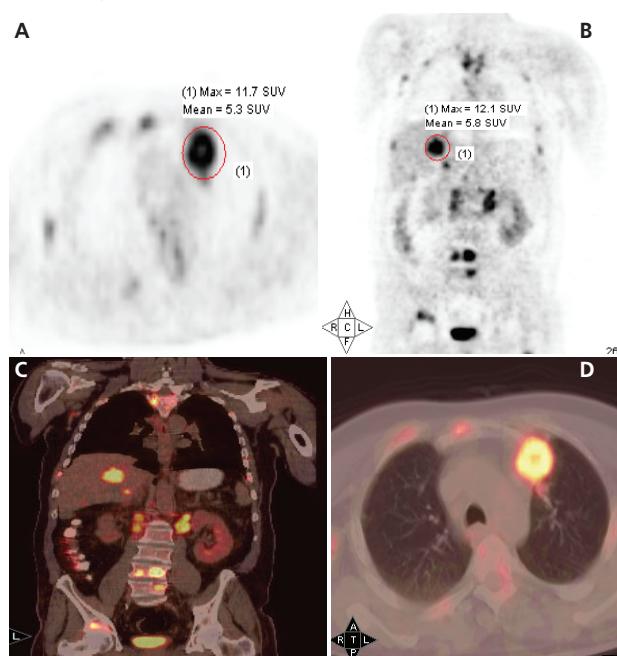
A patient with non-small cell lung carcinoma. The tumor in the left upper lobe shows F-18 FDG uptake (SUV_{max} : 11.7) as well as liver metastasis (SUV_{max} : 12.1). Coronal maximum intensity projection (A) and axial PET images (B) and axial PET/CT images (C), Coronal fused PET/CT images (D). The amount of cfDNA obtained from the patient's plasma was measured as 5 ng/mL. Primary tumor and liver metastasis lesions' SUV_{max} values and cfDNA values were compared. There was no significant difference between primary tumor and metastasis SUV_{max} and cfDNA values
